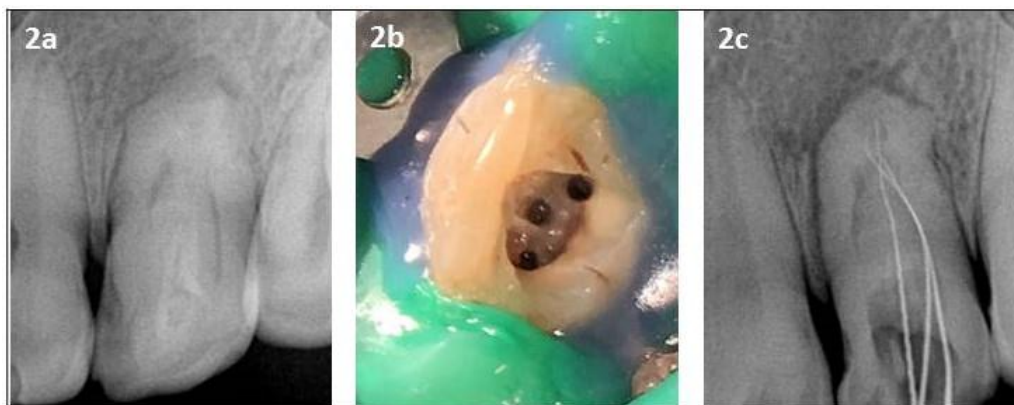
Pre-operative periapical radiography, b: Initial access preparation exhibited three orifices in tooth # 10, c: Working length with three canals (2 buccal and 1 palatal)
